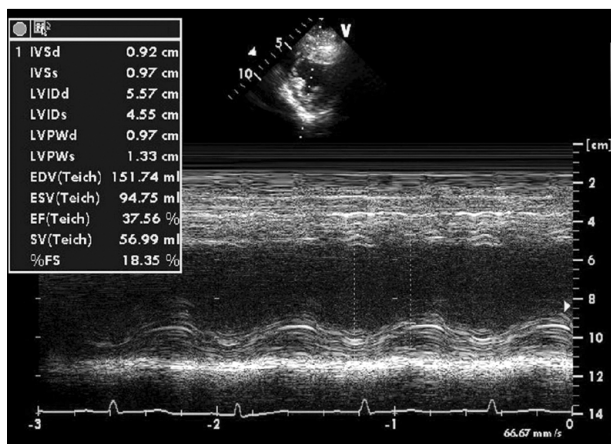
M-mode transthoracic echocardiography in parasternal short axis view two hours after ICU admission. From this view, left ventricle end-diastolic diameter/end-systolic diameter = 56/46 mm and ejection fraction 33% were measured.
